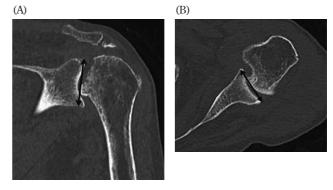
Preoperative CT scan planning for reverse total shoulder arthroplasty (RTSA). (A) The superior-inferior height (arrow) of the glenoid is measured on coronal section. (B) The anterior-posterior width (arrow) of the glenoid is measured on axial section.
